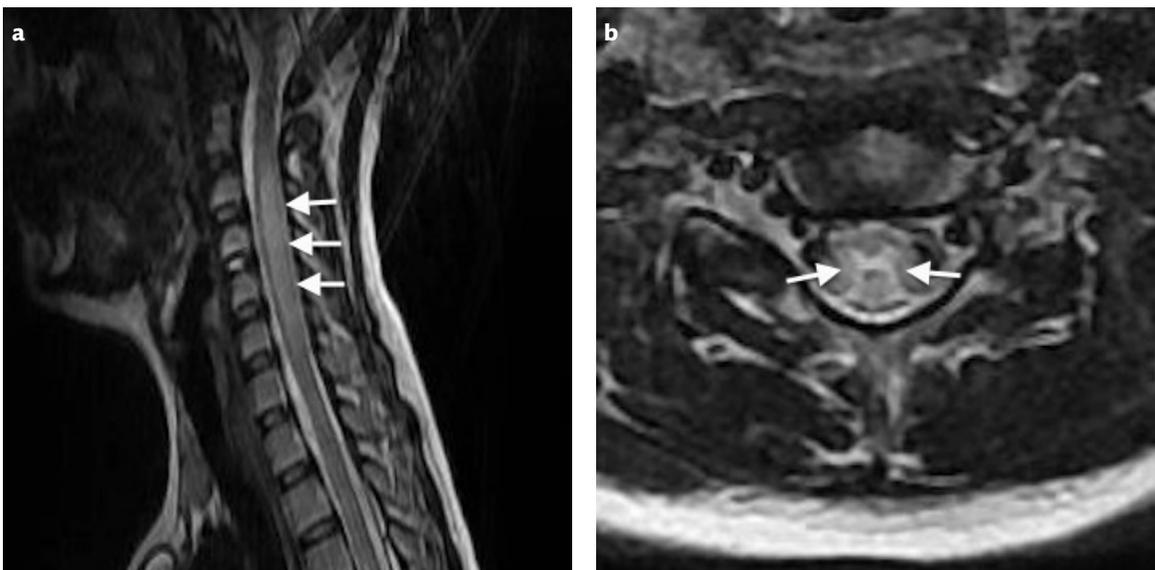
Transverse myelitis. T2-weighted sagittal MR image reveals expansion and increased signal intensity of the cervical spinal cord between the levels of C2-C5 (a, arrows). The gray matter involvement is shown on T2-weighted axial image (b, arrows).
